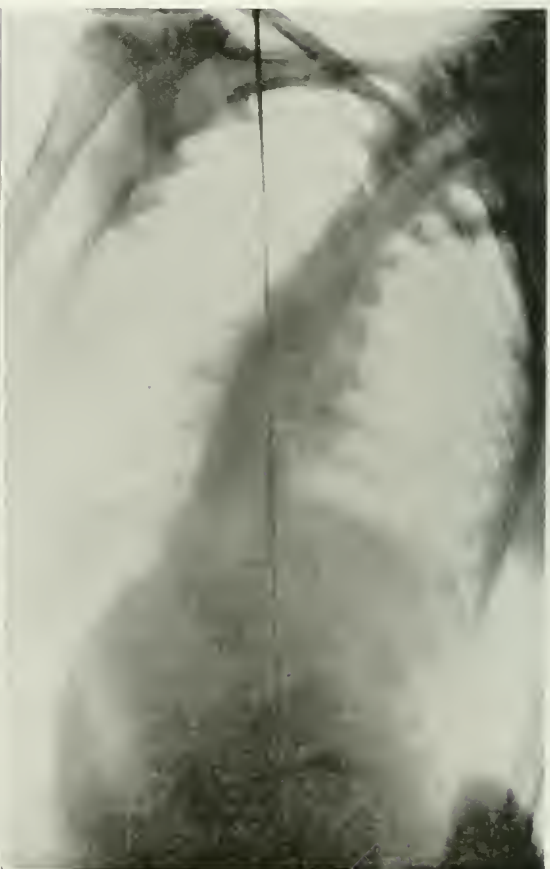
X-ray of same model as in Figure 5, showing spine in left scoliotic position. This with Figure 5 shows the bending in both directions to be symmetrical.
